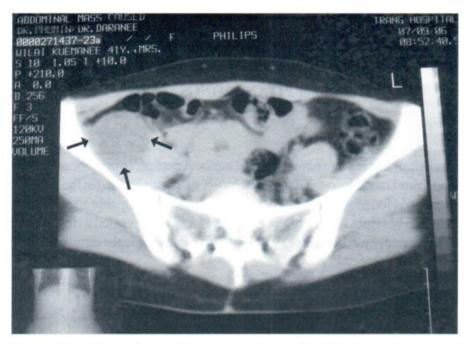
Nonenhanced axial CT scan reveals a well-defined round mass with homogereous hypodensity. The mass is located just lateral to right psoas muscle and anterior to right iliacus muscle.
